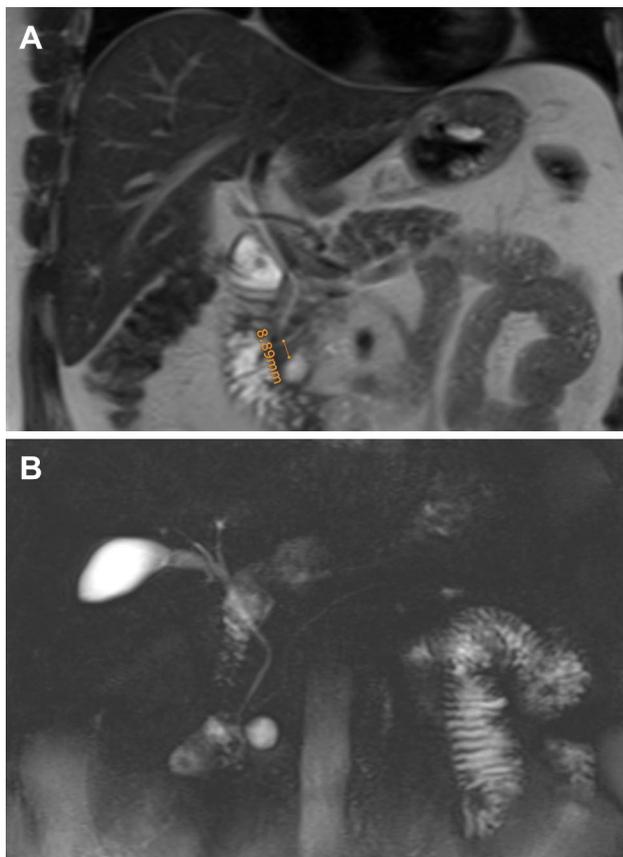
Magnetic resonance imaging. a Coronal view. Cystic NET is seen at approximately 8 mm from the main pancreatic duct. b MR Cholangio-pancreatography shows the cystic tumor in the uncinate process of the pancreas
